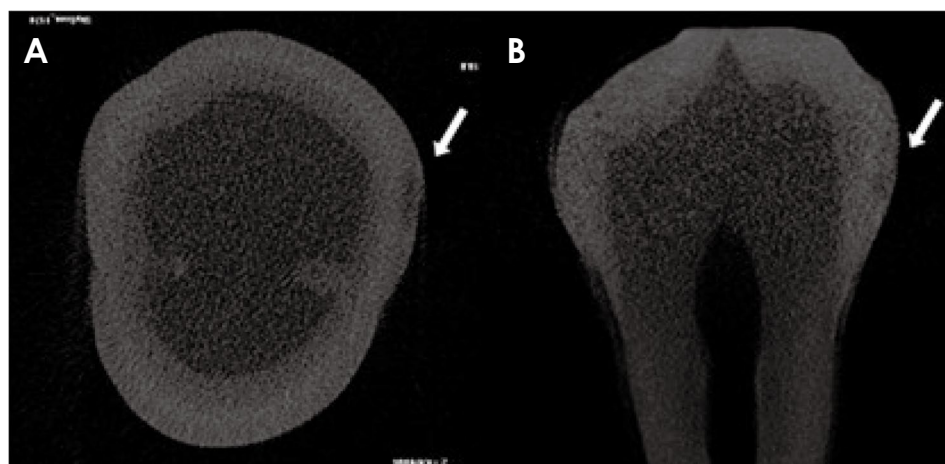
On micro-computed tomography, axial (A) and sagittal (B) reconstructions of the same tooth display a proximal caries lesion (indicated by the white arrows).
